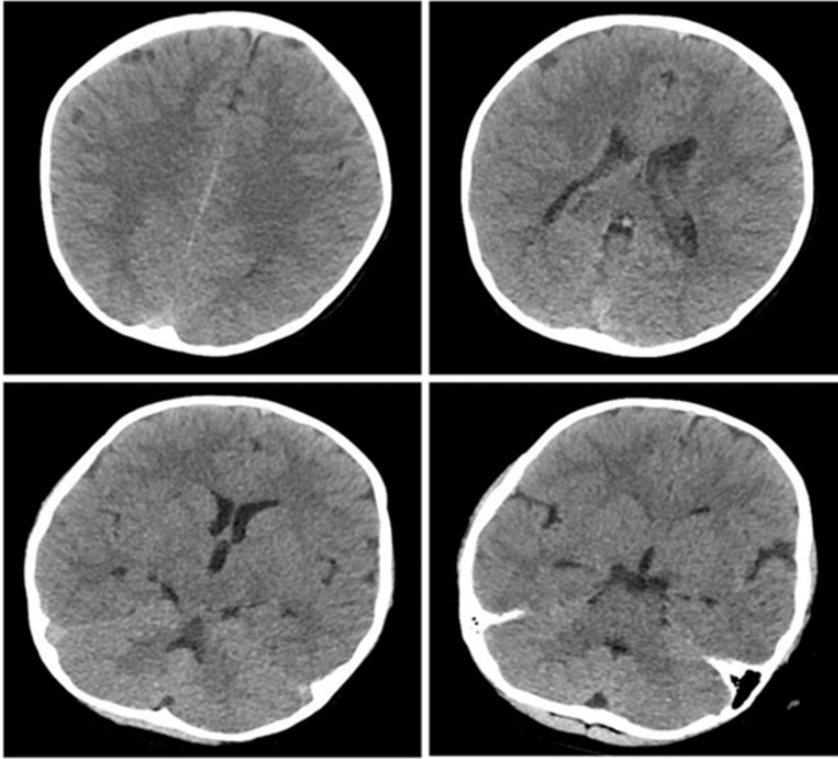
Cranial computed tomography findings in Patient 1.
